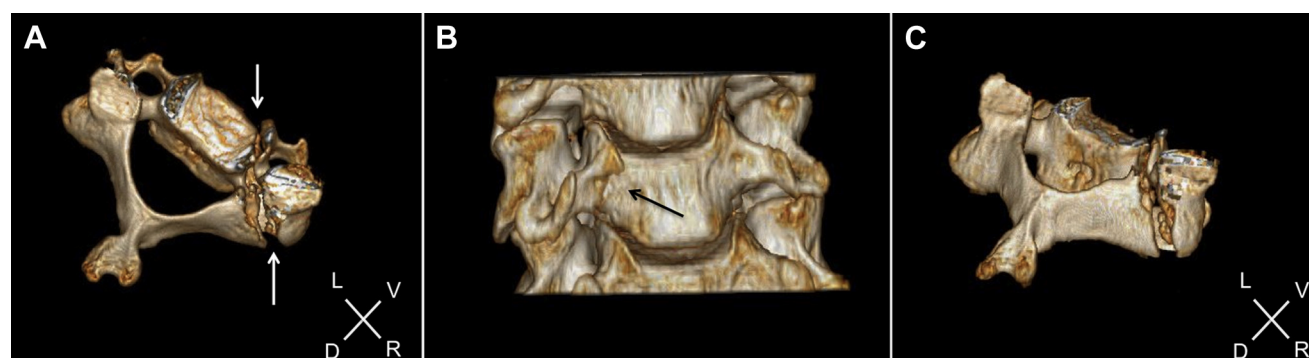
Three-dimensional reconstruction computed tomography scan shows a right vertical split pedicle fracture. (A) Axial view. (B) Anterior
